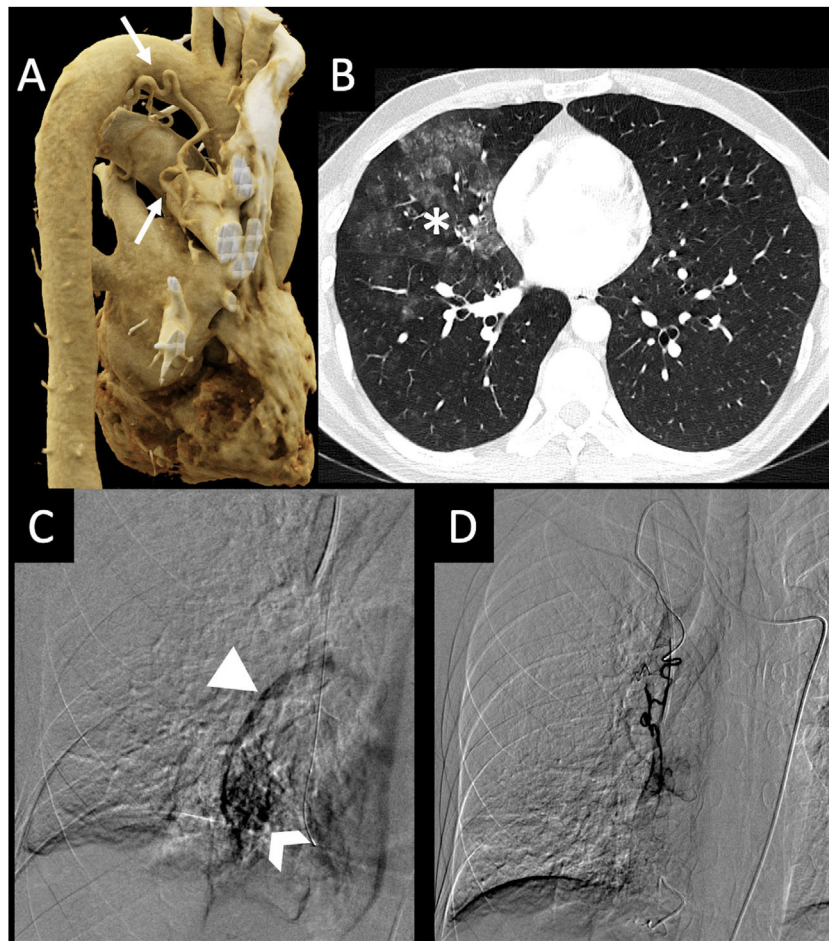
Three-dimensional volumetric reconstruction image of chest CT (A) shows an enlarged ectopic right bronchial artery arising from the undersurface of the aortic arch (arrows). Axial plane pulmonary window CT (B) shows extensive patchy ground-glass opacities in the middle lobe and right lower lobe, consistent with alveolar hemorrhage. Digital subtraction angiography through the right internal mammary artery (C) shows a branch that serves a basal vascular nidus (chevron arrow), which has a direct connection with the respective segmental pulmonary vein (arrowhead). Successful embolization of the lesion was performed (D). These findings are compatible with angiographic findings of bronchial Dieulafoy's disease.
